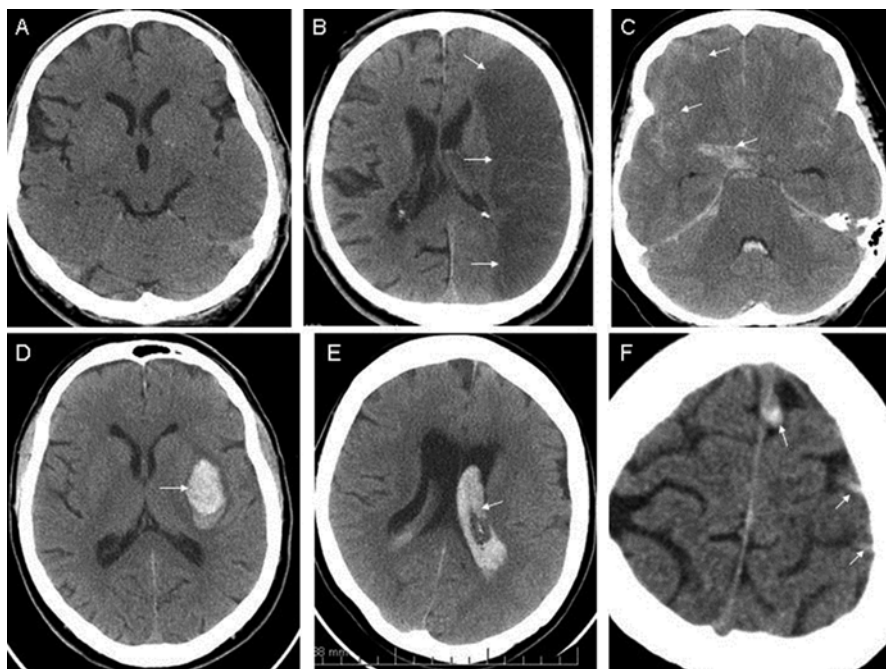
Ischemic and haemorrhagic stroke on CT. (a) Normal CT (typical baseline finding in patients with acute ischemia); (b) acute ischemia 24 h after stroke onset (hypodense area marked by *white arrows*); (c) subarachnoid haemorrhage (hyperdense signal marked by *white arrows*); (d) intracerebral haemorrhage (ICH); (e) intraventricular haemorrhage; (f) cortical vein/dural sinus thrombosis (hyperintensities represents acute clots in cortical vein and superior sagittal sinus)
